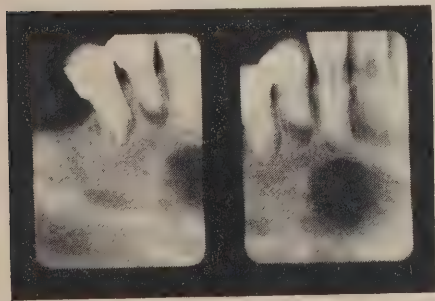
Roentgenogram taken September 12, 1947.
